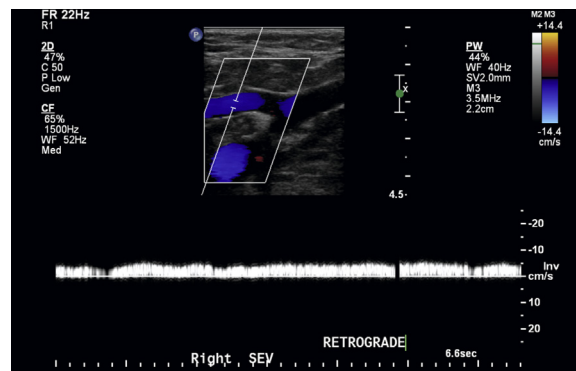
Color Doppler of the superficial epigastric vein (SEV) demonstrates reversal of physiologic flow.
